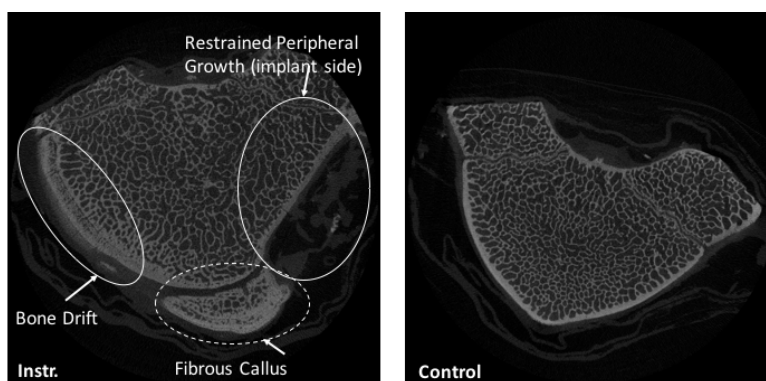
Instrumented vs. Control transverse CT cuts showing possible signs of restrained bone growth, bone drift phenomenon, and fibrous callus formation.
